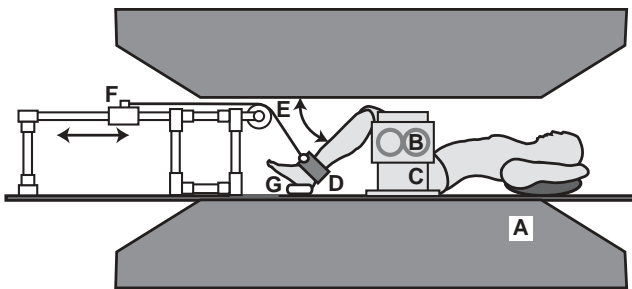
Experimental setup. The subject was positioned supine in the MRI scanner (A). Dual general-purpose radiofrequency coils (B) were held on vertical supports (C) on either side of the limb being imaged. The subject's ankle was placed in a cuff (D) attached to ropes that pass over a pulley (E) and attach to the handle of a slider mechanism (F). The subject's knee was moved through extension and flexion during cine-PC MR image acquisition by moving the slider handle on the device. An optical transducer (G) placed near the foot triggered the beginning of each motion cycle.
